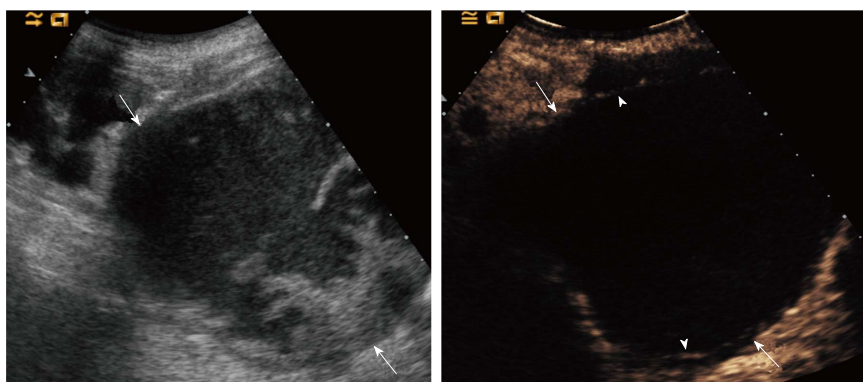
Patient with grade IV chronic renal failure. A: Grey-scale ultrasound showed a complex renal lesion (arrows). Contrast enhanced ultrasound showed no intralesional enhancement, nor vegetations; B: Two thin septa were visible (arrowheads) with minimum enhancement (benign minimally complicated cysts, Bosniak category II).
